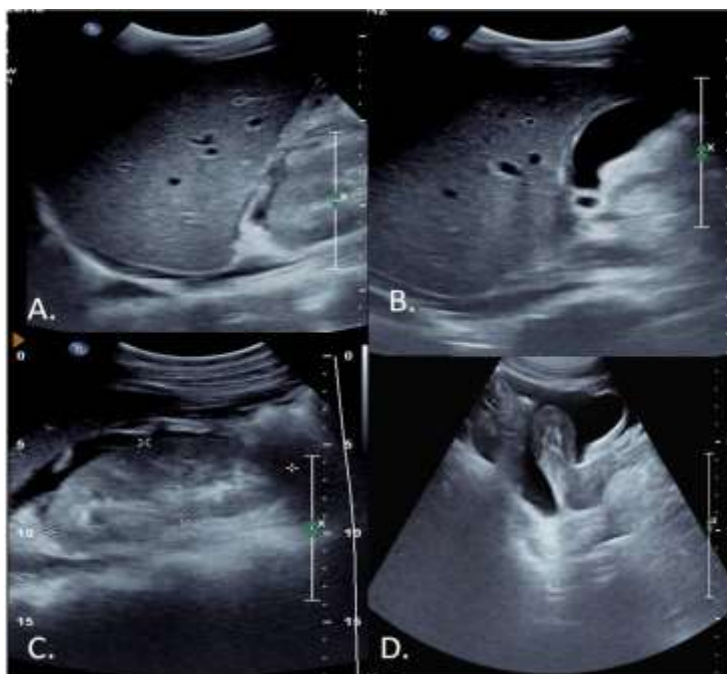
[A-D]:- Sonographic images were showing polyserositis in form of pleural, peri-hepatic and pelvic collection.
